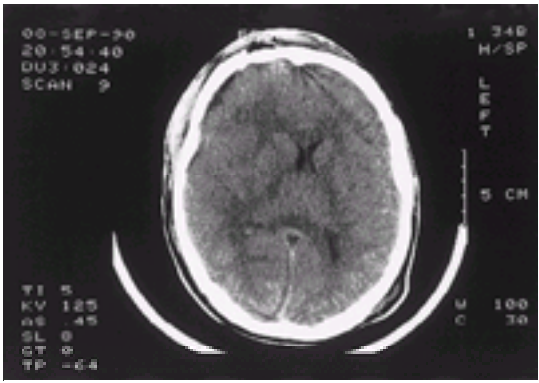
CT 3 days later of patient shown in [Fig. 1](#), showing subdural pus situated along the right side of the falx posteriorly. Parafalcine pus often occurs with subdural abscess. The extradural pus and convexity subdural pus have been evacuated.
